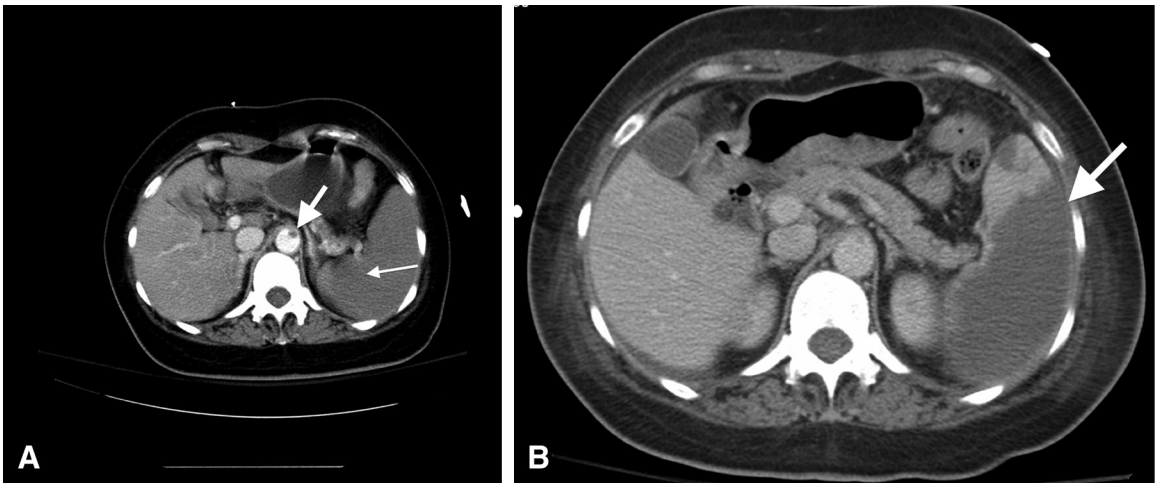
(A) Computed tomography scan of the abdomen with i.v. contrast performed on hospital day 1 showing 1-cm filling defect in the anterior aspect of the abdominal aorta (thick arrow) and hypodense spleen representing splenic infarction (thin arrow). Poor visualization of splenic artery. (B) Computed tomography scan of the abdomen with i.v. contrast completed on hospital day 3 showing extension of splenic infarct.
